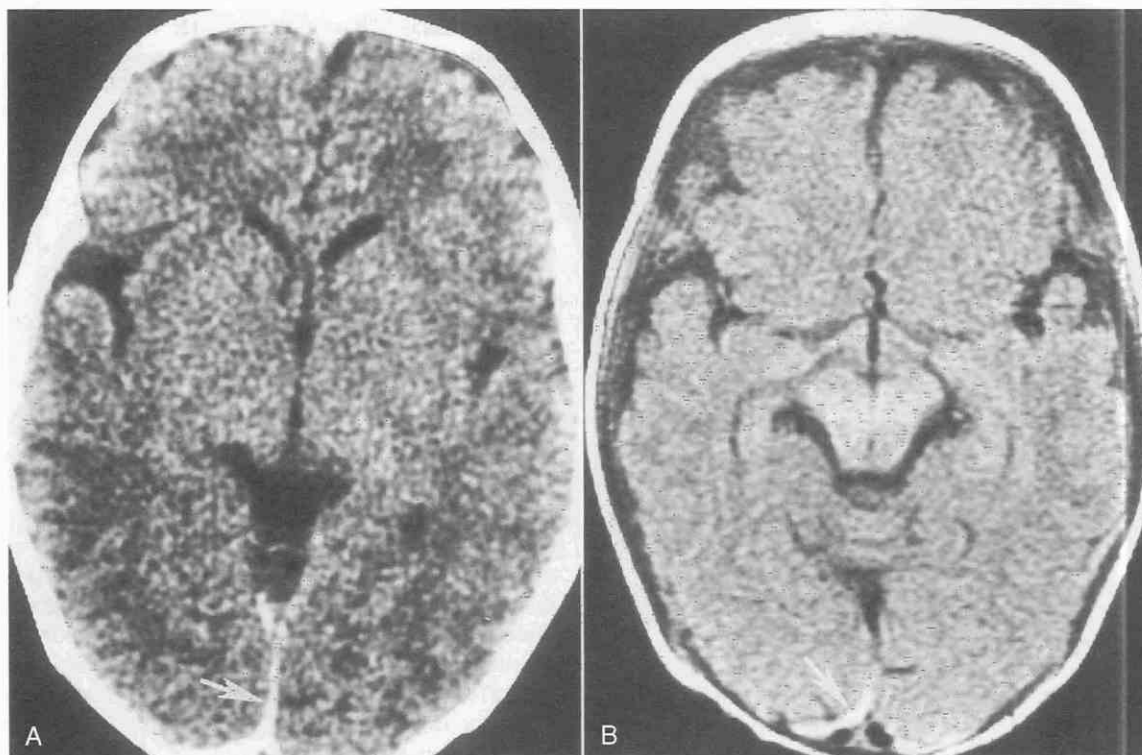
A and B, Child abuse. Axial CT scans show an acute posterior interhemispheric subdural hemorrhage in the occipital area (arrows).
